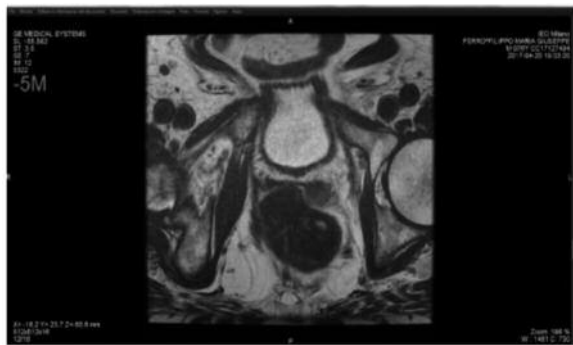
MRI image showing macroscopic disease recurrence in left prostatic bed (diameter: 17 mm).
